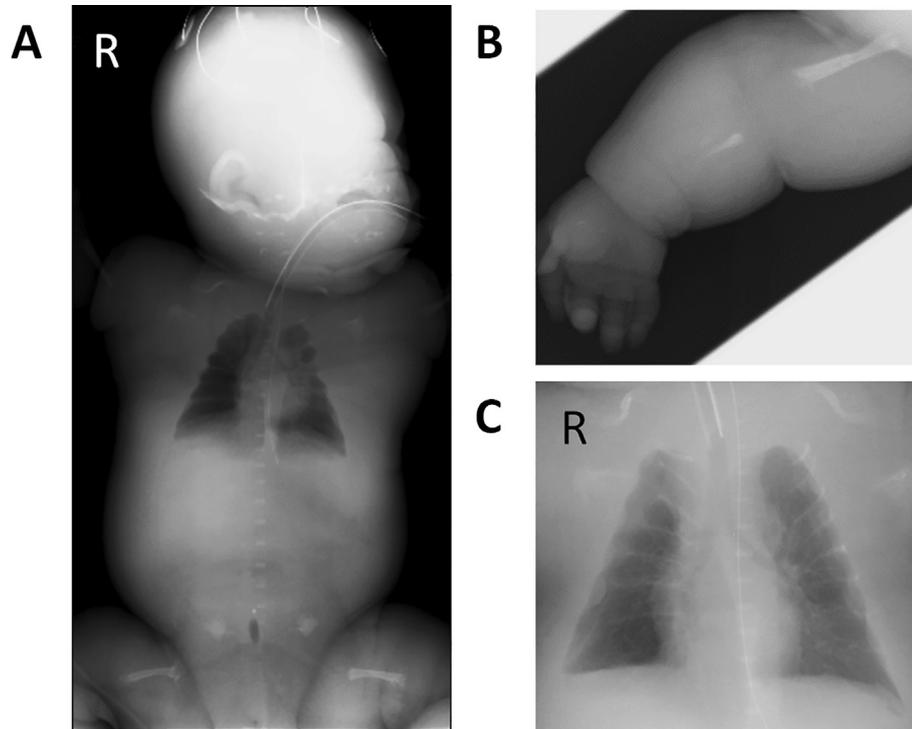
X-ray photographs at birth. A) Markedly low ossification of the bone and pulmonary hypoplasia were observed. B) Shortening of the right upper limb bone. Flaring of the humerus was observed. C) The ribs were extremely narrow.
